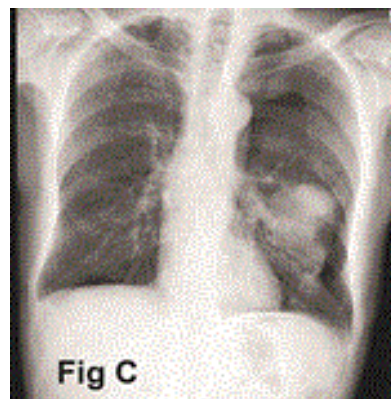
A chest x-ray after biopsy showing a left-sided pneumothorax with the tumor in the left upper lobe separated from chest wall indicating no invasion to the lateral chest wall.
